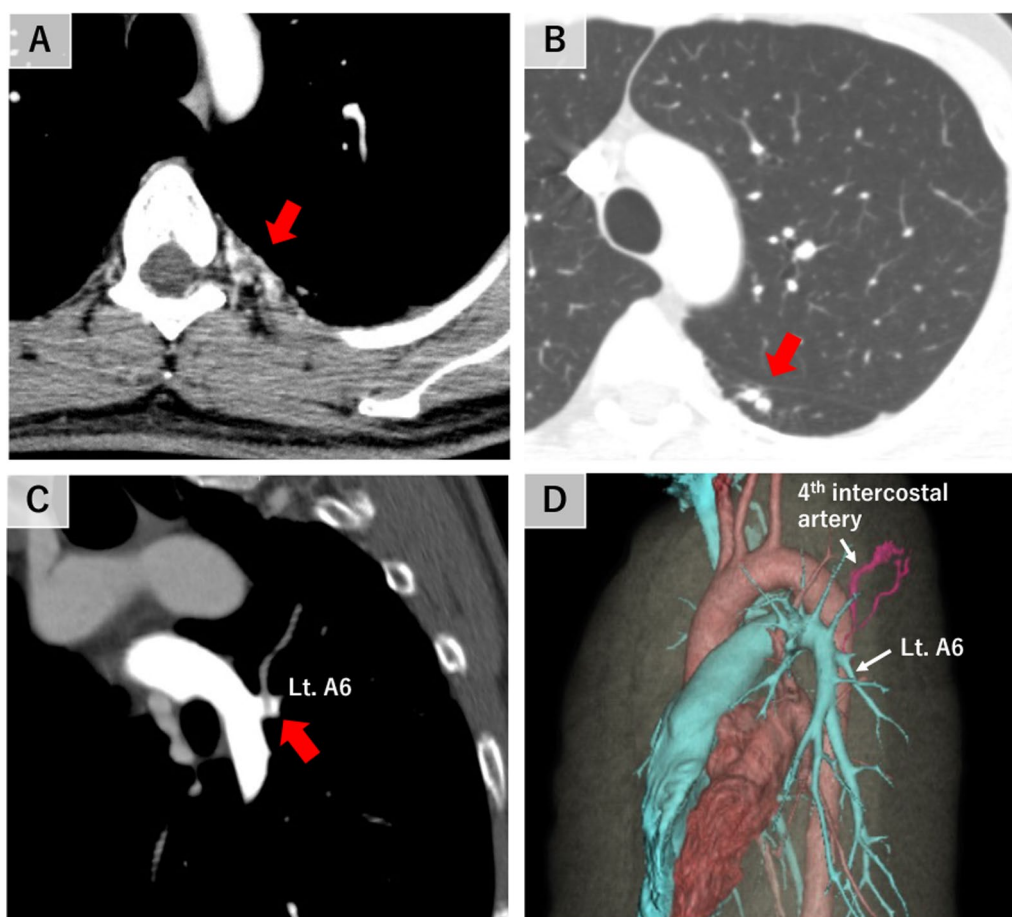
Computed tomographic images of the retrograde systemic to pulmonary artery shunt. A Numerous neovascular vessels in the left chest wall (red arrow). B Anomalous arteries in the left lower lobe superior segment of lung (Lt. S6, red arrow). C Filling defect in the left apical segmental pulmonary artery of the left lower lobe (Lt. A6, red arrow). D In the three-dimension (3D) image, the 4th intercostal artery, a systemic artery, flowed into the left apical segmental pulmonary artery of the left lower lobe (Lt. A6), which was diagnosed as the systemic-to-pulmonary artery shunt (SPAS)
